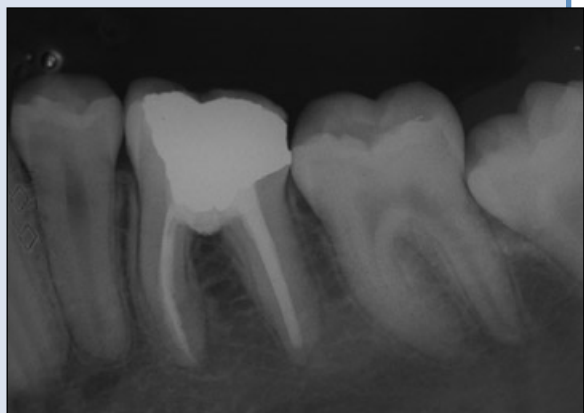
Case 1. Periapical image of tooth 36 showing caries-related furcal perforation.
